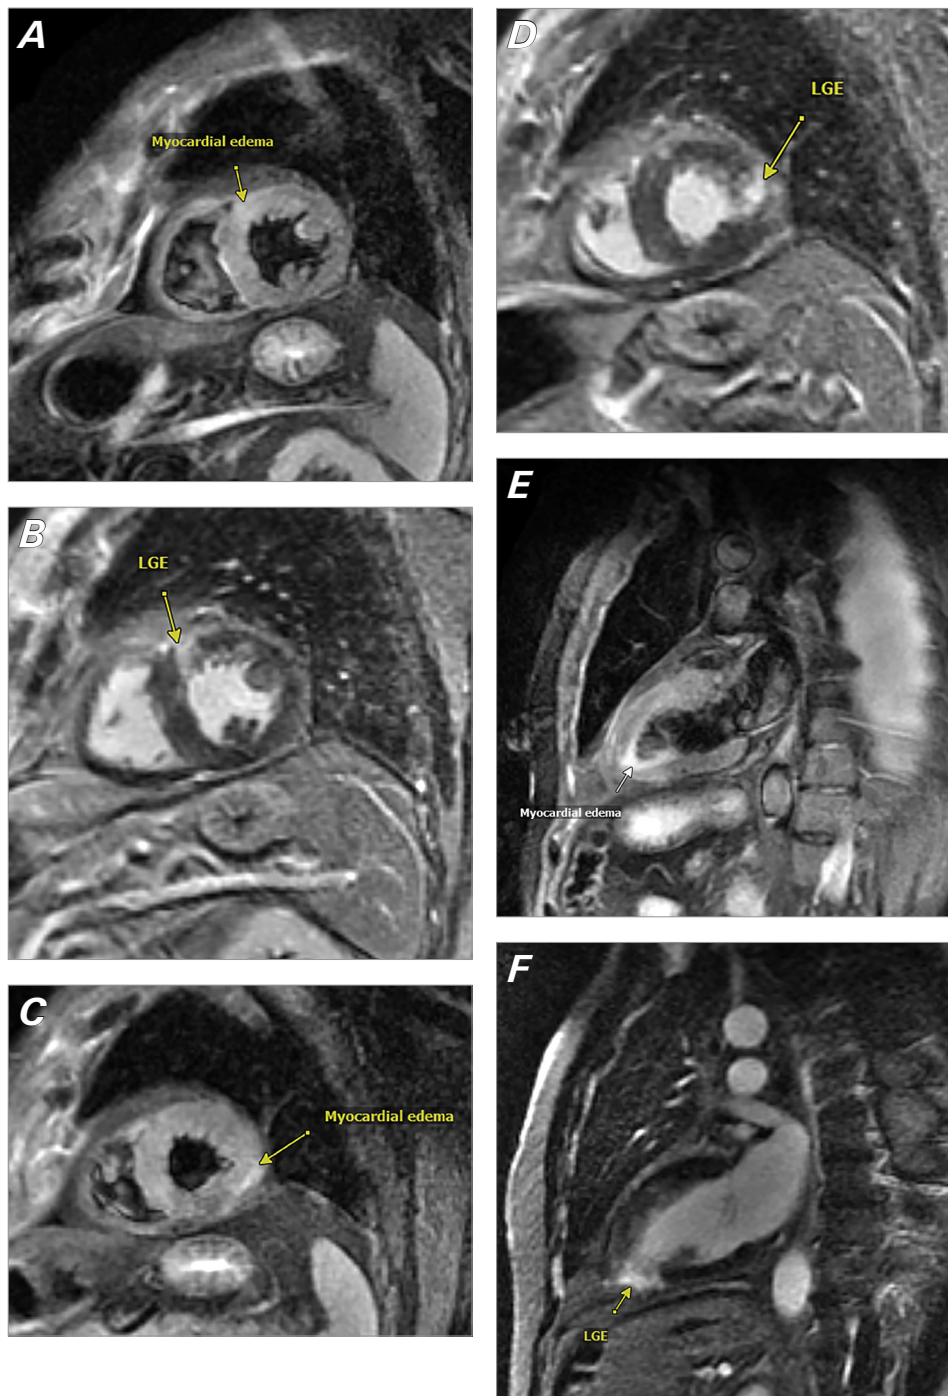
Cardiac magnetic resonance images show myocardial edema in a triple inversion sequence (A, C, E) and its corresponding transmurals LGE (B, D, F) in the (A, B) midanterior segment, (C, D) apical lateral segment, and (E, F) apical inferior segment. LGE, late gadolinium enhancement.
